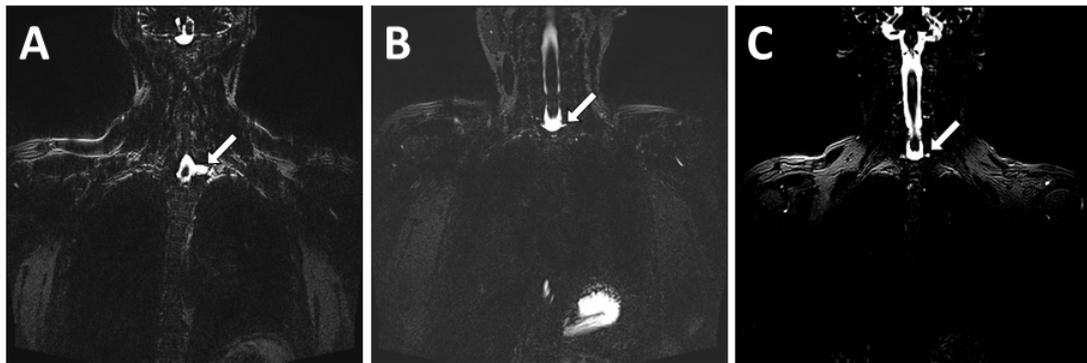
Coronal view of the T2-weighted whole spine MRI performed in three of the four patients, showing extradural CSF leakage. A. Patient 1, CSF leakage at left T1-2 level; B. Patient 3, CSF leakage at bilateral C-T junction; C. Patient 4, CSF leakage at bilateral C-T junction.
